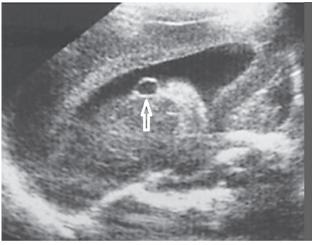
Para sagittal and Coronal view cranial sonography shows thin walled cyst (arrow) in the left choroid plexus of lateral ventricle
